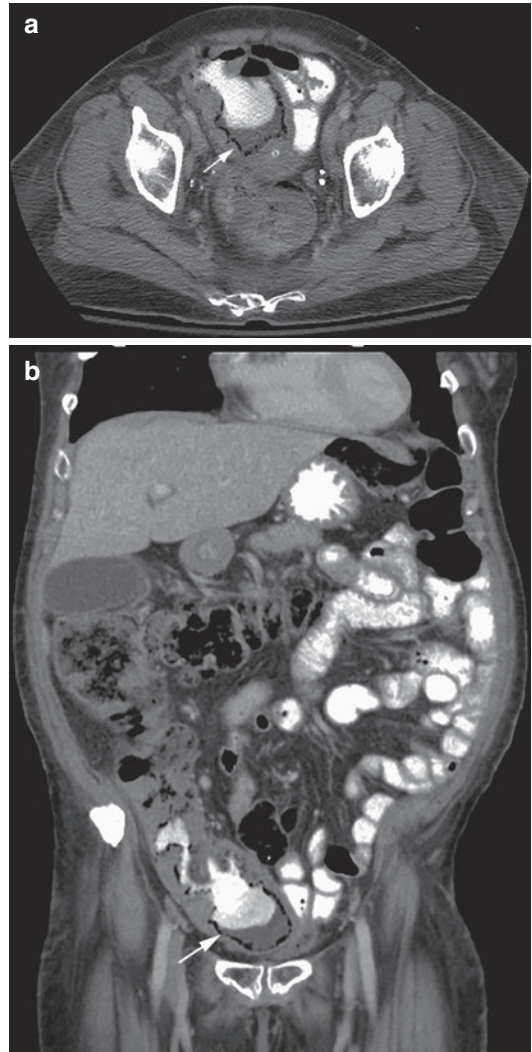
A 70-year-old female with CLL status post bone marrow transplantation and neutropenia presents with right upper and lower quadrant abdominal pain. (a) Axial CT shows marked thickening of the cecal pole with circumferential pneumatosis intestinalis (*arrow*). (b) Coronal CT demonstrates cecal and ascending colonic wall thickening and circumferential pneumatosis intestinalis (*arrow*) consistent with typhlitis in this neutropenic patient
